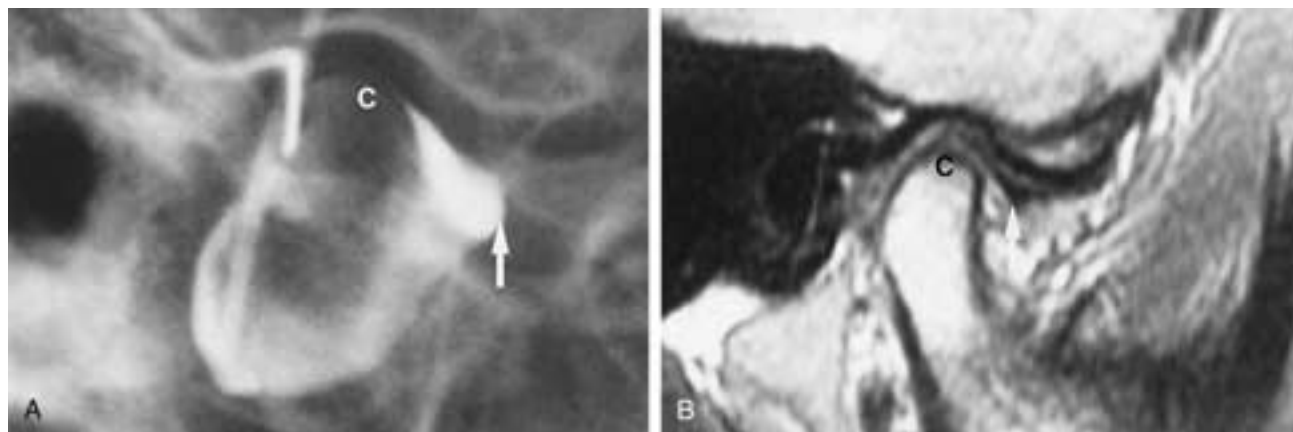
A, Arthrogram. B, MR image of the same TMJ showing the normal superior disk position. The anterior recess of the lower joint compartment is indicated by an arrow in the arthrogram. In the MR image the disk is located superior to the condyle. The condyle (C) is noted in both studies.
